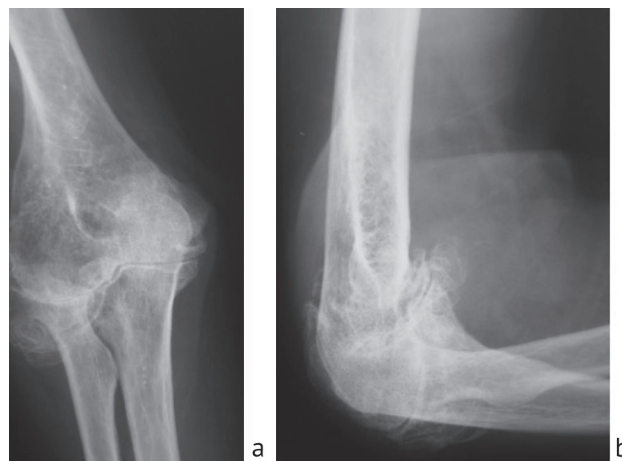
Patient N radiographs of the elbow joint before the operation: a – AP view; b – lateral view
